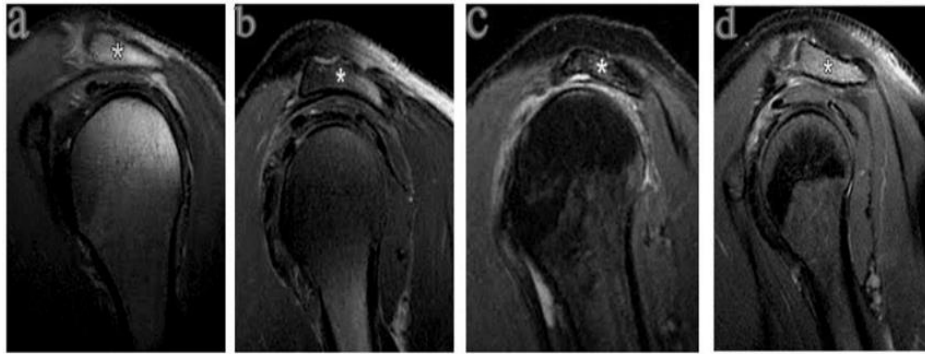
Classification of Acromial Morphology as evidenced by MRI (T2WI);
